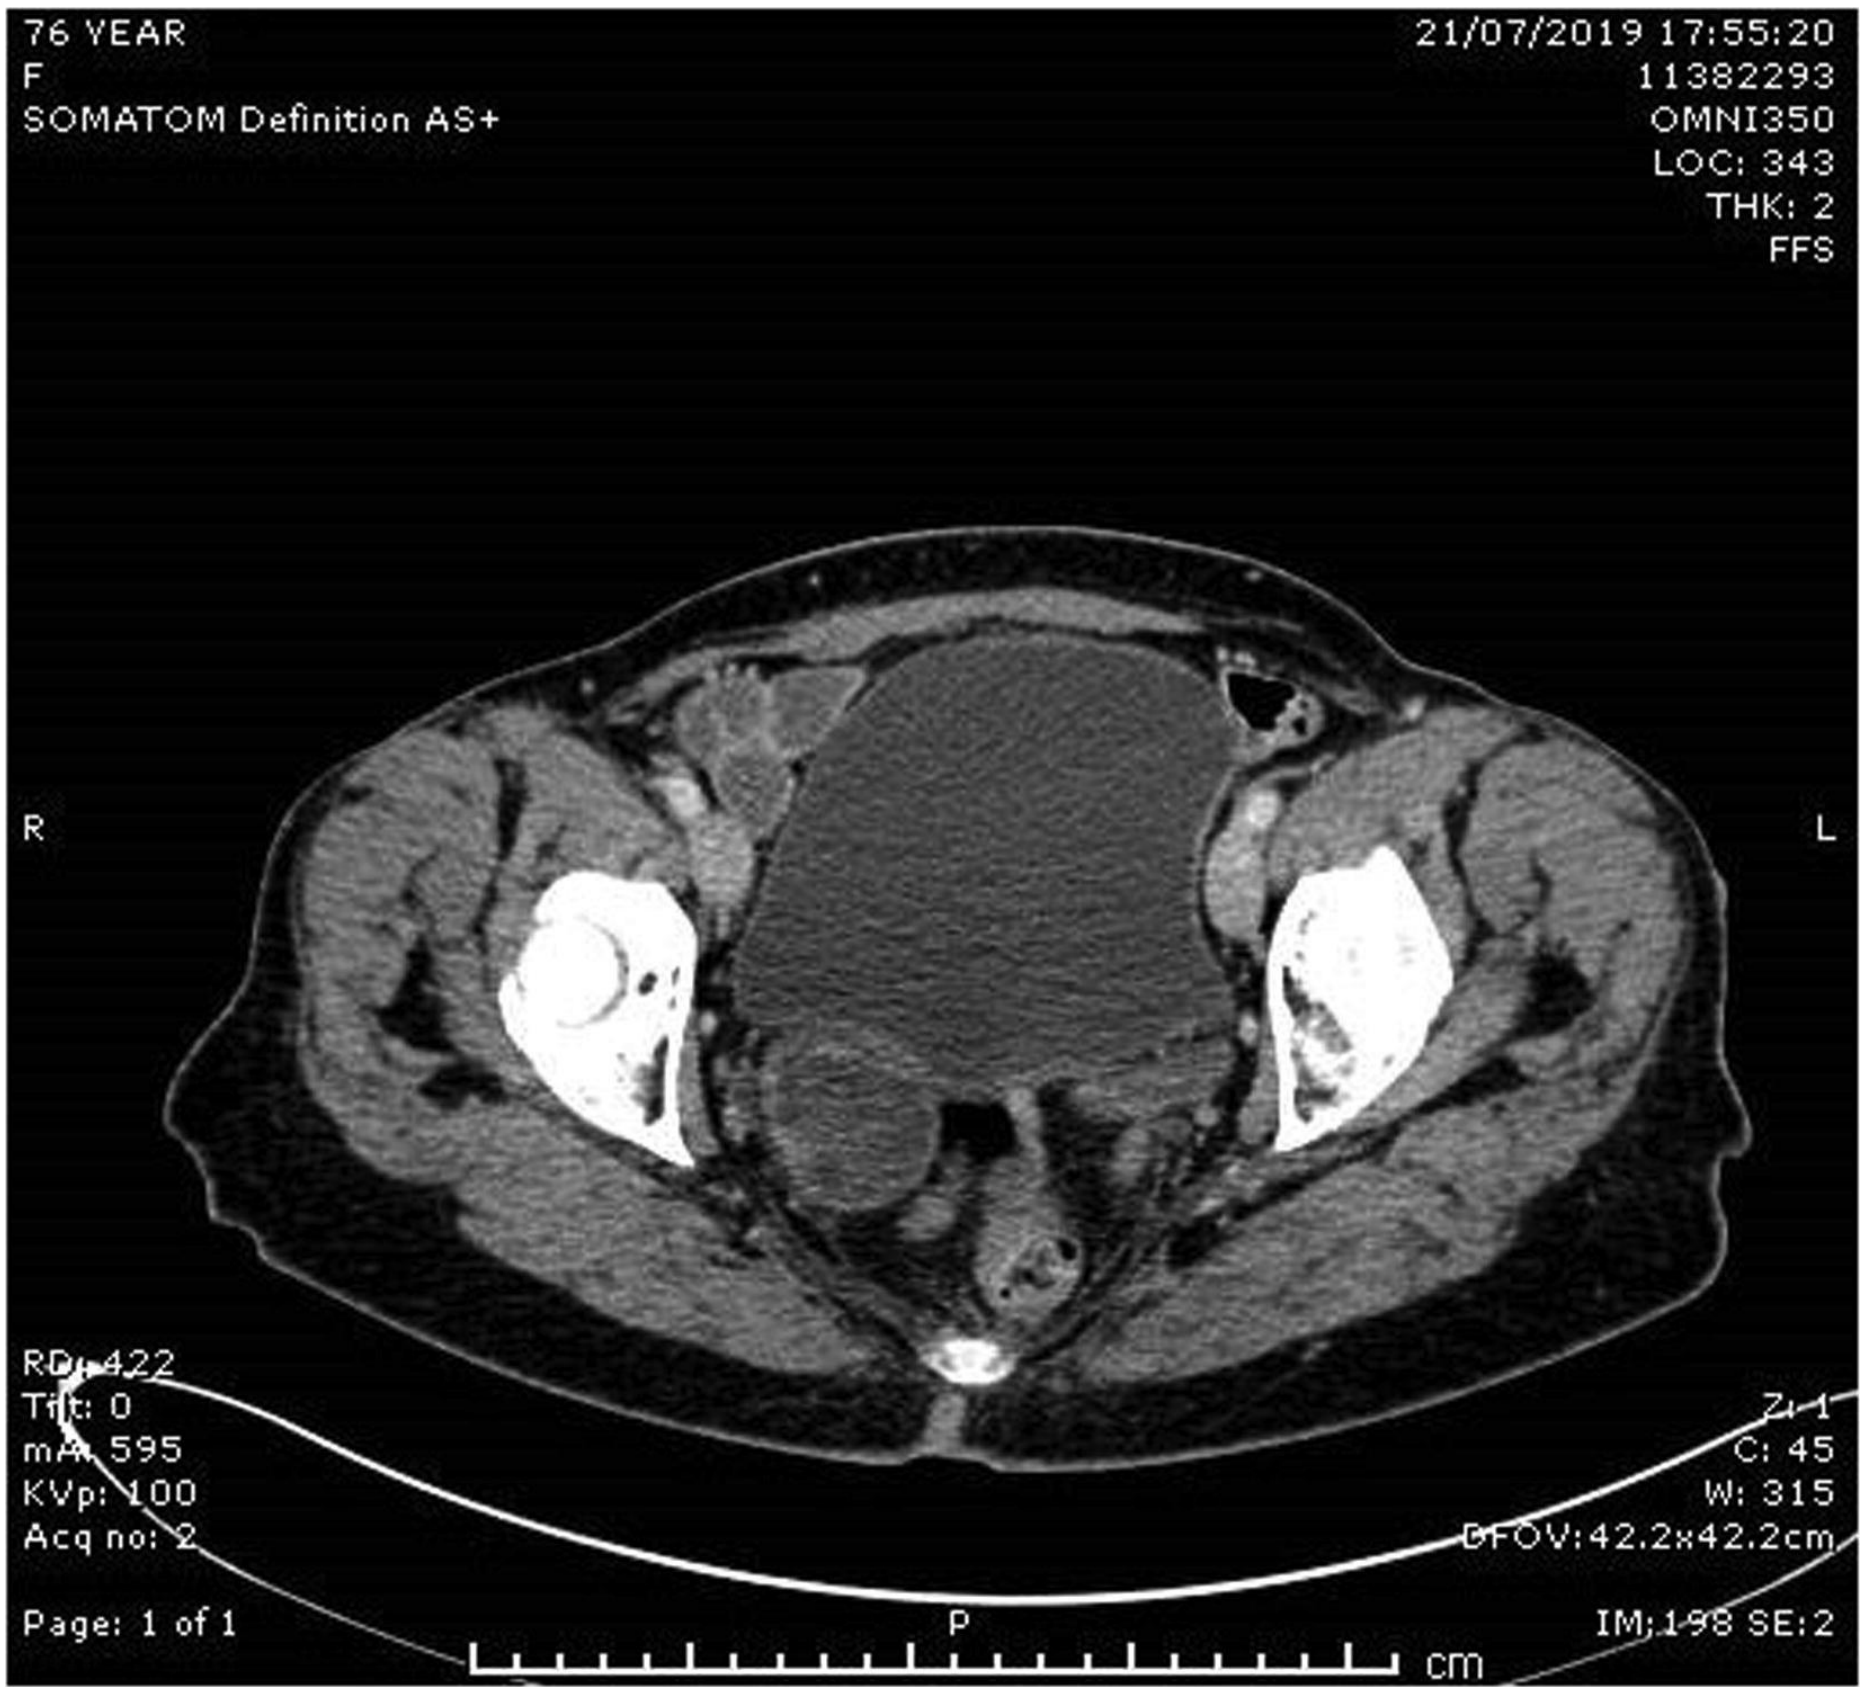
CT scan showing minimally complex right ovarian cyst.
